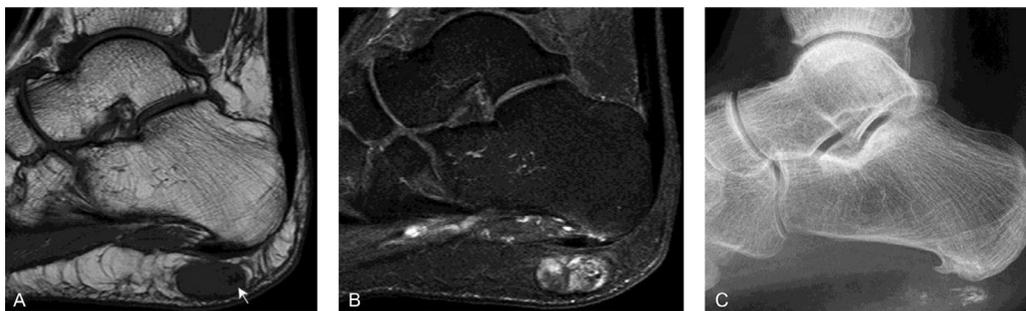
Angiomyoma. (A) Sagittal T1WI shows a small, ovoid, and subcutaneous mass in the heel. It shows iso intense signal to the muscle with hypointense foci that are in keeping with calcifications (white arrow). (B) Sagittal fat saturated postcontrast T1WI shows heterogeneous contrast enhancement. (C) Lateral radiograph of the foot shows calcifications. T1WI, T1-weighted images.
